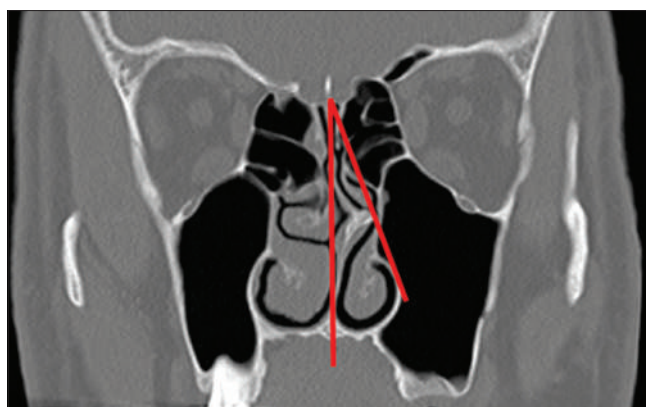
Coronal CT image showing SDA measurement with significant deviation to the left, CT: Computed tomography, SDA: Septal deviation angle
